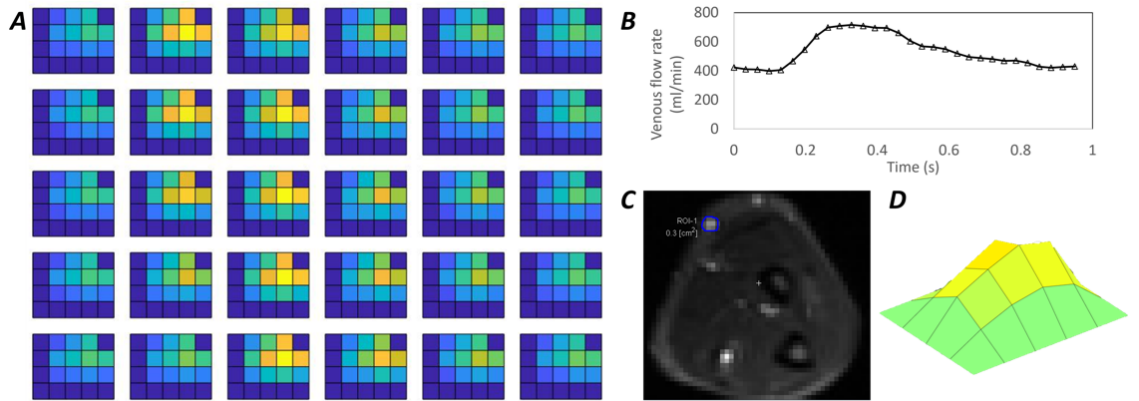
Flow waveform profile example from the PC-MRI using FeMRA.
